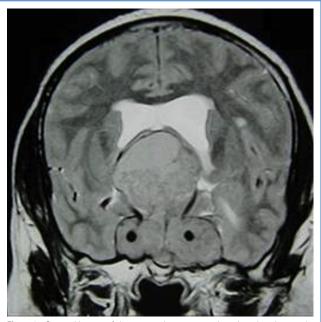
Coronal image of the magnetic resonance imaging showing grade II tumor. Both cavernous sinuses are invaded by the tumor.
